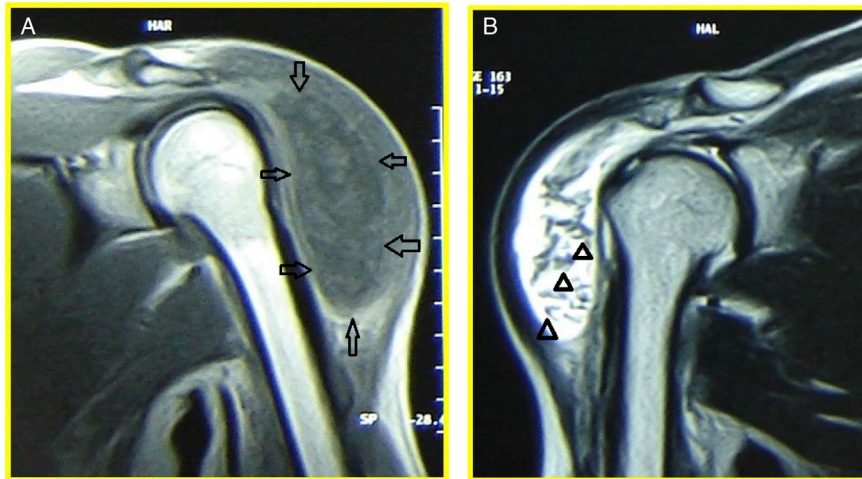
MRI of both shoulder – large homogeneous intermediate signal intensity lesion similar to that of muscle on T1 weighted images in the subdeltoid aspect of the bilateral shoulder (arrows) which appear high signal intensity on T2 weighted images. Multiple small discrete nodular areas (arrow heads) of low signal intensity within the lesion also noted in T2 weighted image.
